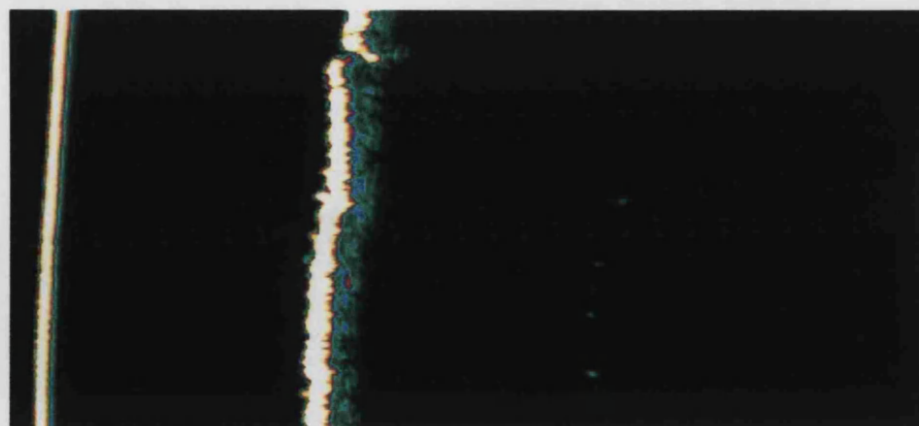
Examples of ultrasound images taken from the a. dorsum, b. medial longitudinal arch and c. plantar metatarsal area on the feet.
